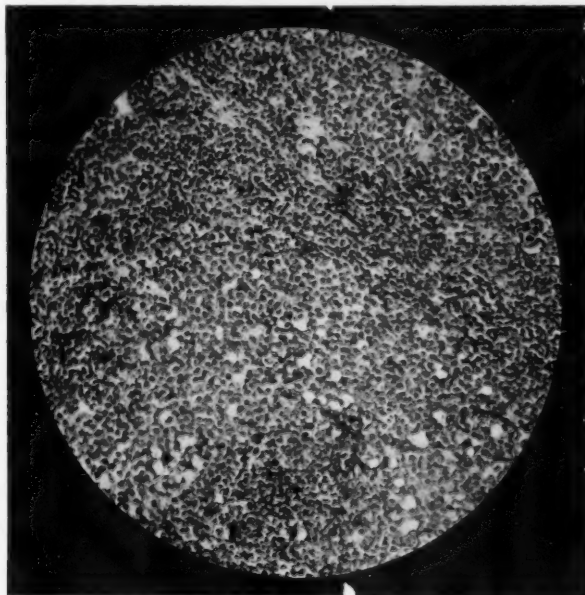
Case 15, Tonsil table. Before toxin treatment. Inoperable lymphosarcoma of tonsil and neck. Nearly disappeared after two months' toxin treatment, but then increased slightly. Removed by operation, and toxin treatment again given. Improved under radium and X-ray; later recurred. Still under treatment.
